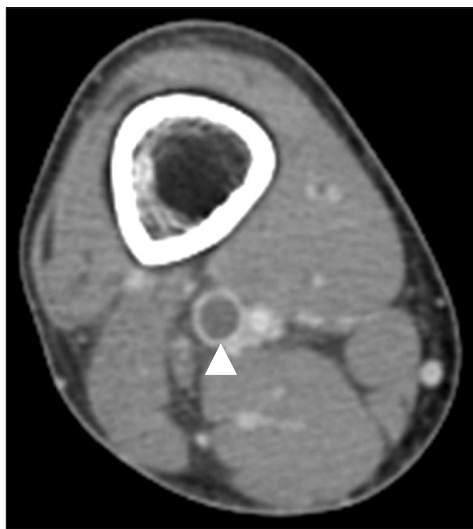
Computed tomography angiogram of the right lower extremity. A dark filling defect (arrowhead) is visible in the right popliteal vein, which is consistent with deep vein thrombosis.
